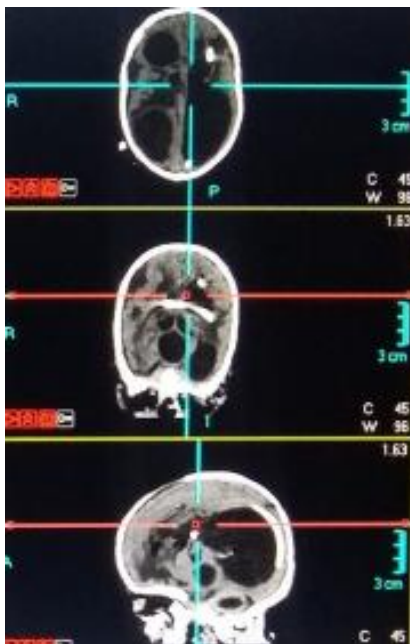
CT Scan with Multi Planar Reconstruction (MPR) Views of EVD Tube Migration.
